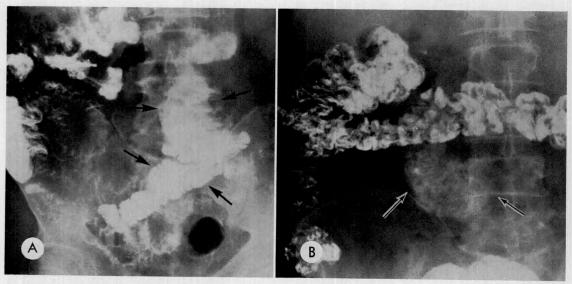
Case IV. (A) The  $2\frac{1}{2}$  hour interval roentgenogram of a serial barium study of the small intestine reveals a markedly distended segment of small intestine in the mid-abdomen (arrows). Note the density of barium in this pouch and the more dilute barium in the terminal loops of ileum. The ascending and proximal transverse segments of colon are filled and in these the barium is equal in density to that in the pouch. (B) The 24 hour roentgenogram of the serial study reveals that all of the orally ingested barium is in the colon with the exception of a small quantity which is retained in the pouch seen at the inferior aspect of the transverse colon (arrows).
